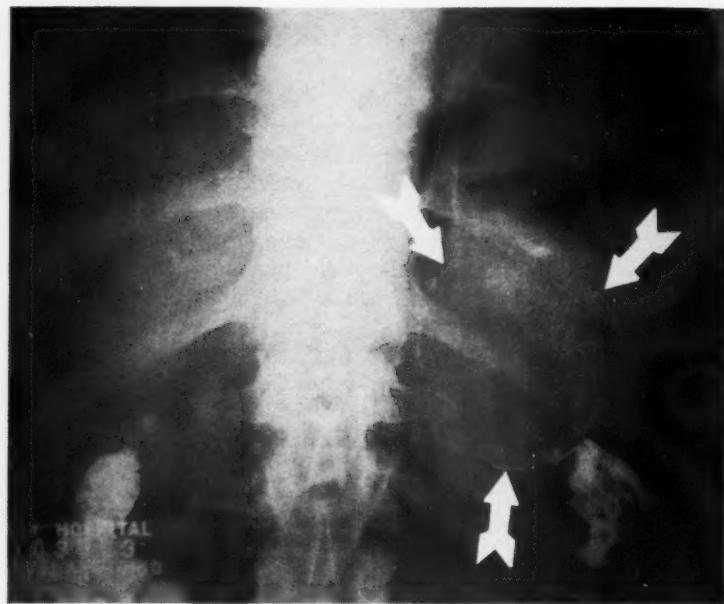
Anteroposterior roentgenogram showing a large round calcified aneurysm of the splenic artery in the left upper abdomen, measuring 9 cm. in diameter. Calcified gallstones are present in the right upper abdomen.
